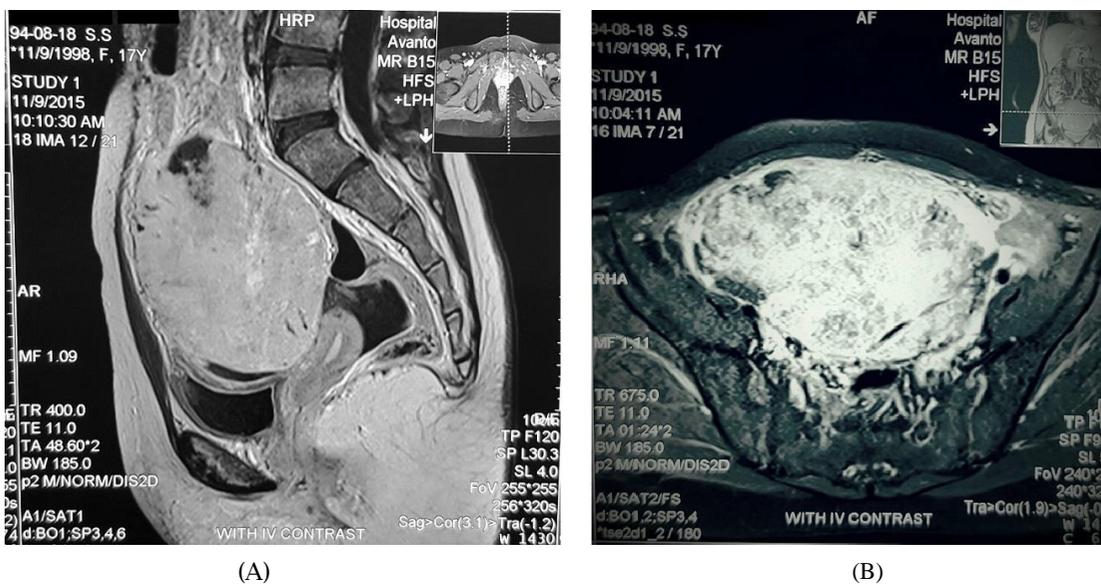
Pelvic MRI with contrast of patient, (A) Sagittal view (B) Axial view
